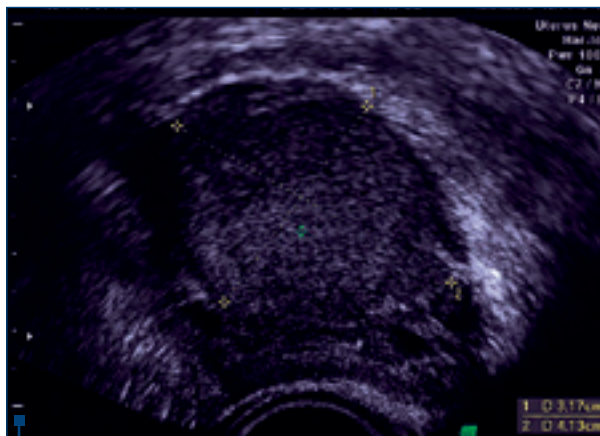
Ovarian endometrioma aspect in 2D ultrasound
